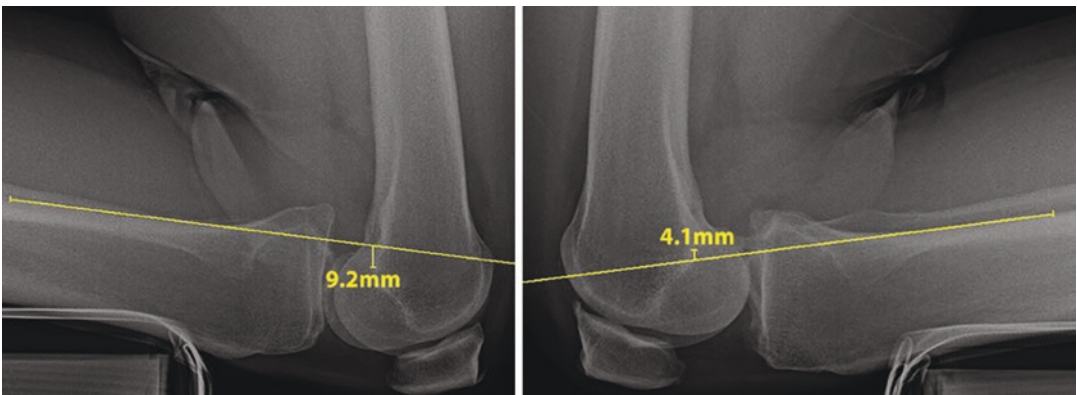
Preoperative stress radiographs are important in evaluating patients with knee ligament injuries. In this patient, there was a 13.3 mm increase in posterior tibial translation on the left compared to the right knee, consistent with a combined PCL injury. To compare the posterior tibial translation, a point is identified along the posterior tibial cortex 15 cm distal to the joint line. A line is then drawn from this point parallel to the posterior cortex, through the femoral condyles. The most posterior point of Blumensaat's line is marked. A perpendicular line is drawn from the most posterior point of the Blumensaat's
